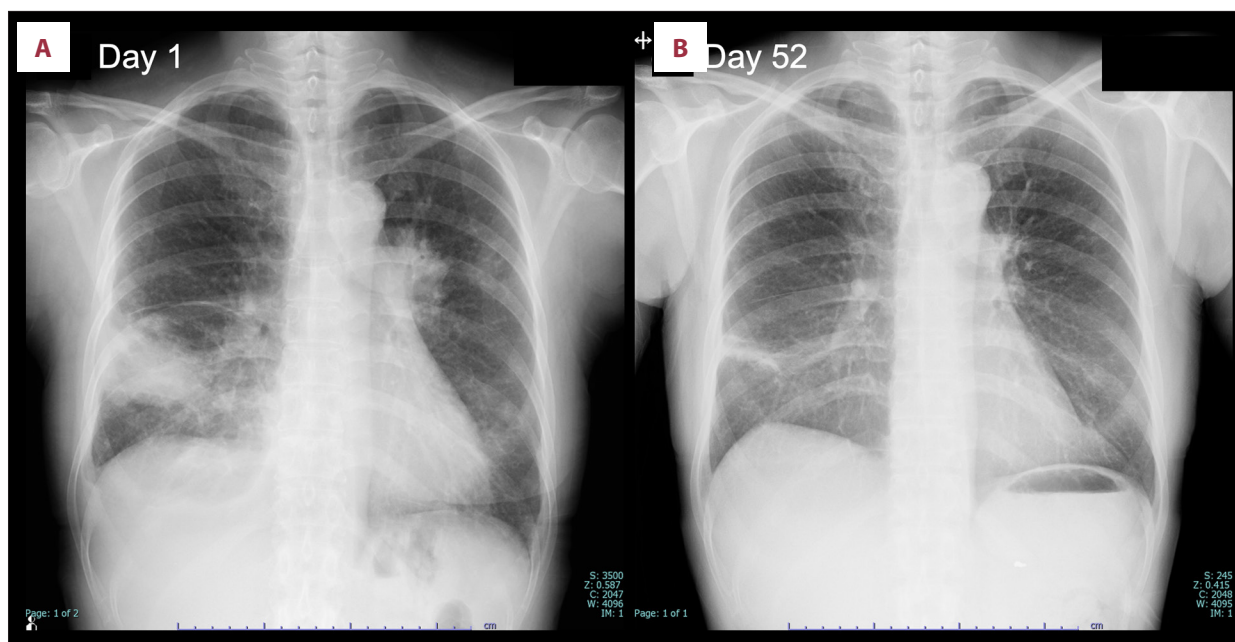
Chest radiographic improvement after treatment. Chest radiography on hospital day 1 showed bilateral lower-lung opacities, including dense consolidation in the right lower lung field (A). By hospital day 52, these opacities had substantially decreased; only a residual band-like opacity was evident in the right lower lung field after antimicrobial and antifungal therapy (B).
